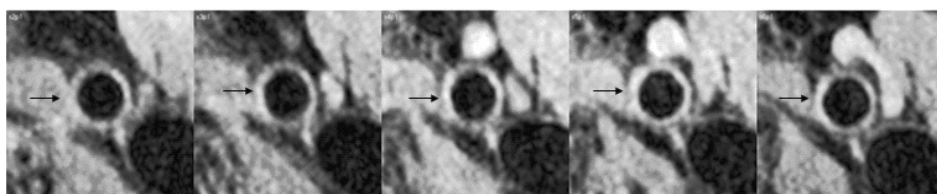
Representative example of 3-Tesla MRI image of the carotid artery of a 62-year old male subject. Black arrows indicate the carotid artery. Five contiguous transverse slices of 2mm, covering the most distal 1cm of the common carotid artery are shown.
